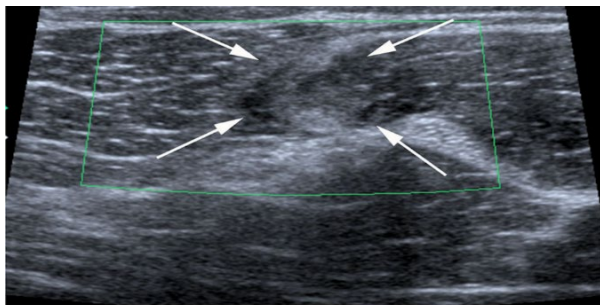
Longitudinal ultrasound image showing grade 3 muscle rupture with complete fiber discontinuity and intervening hematoma.
